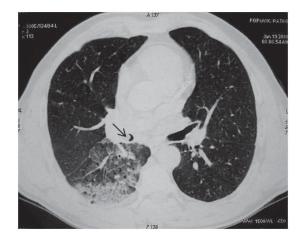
Chest CT in a patient with lipoma shows round tumour in bronchus intermedius and signs of inflammation.
